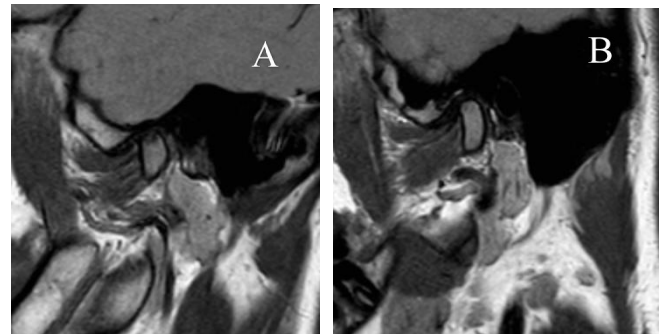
Magnetic resonance imaging (MRI) for TMJ-OA confirmation of diagnosis.
